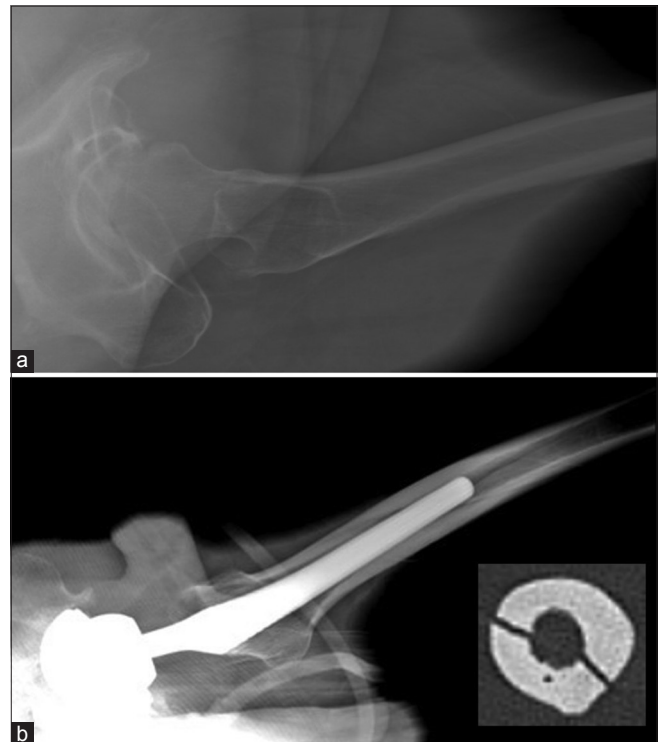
Cross-table lateral hip radiographs of a 68-year-old female (a and b). (a) No radiolucent line is seen in the femoral diaphysis preoperatively. (b) At below the implant tip, oblique radiolucent line (white arrow) is seen postoperatively. (c) Subsequent 6 axial computed tomography images from distal to proximal shows a nutrient artery canal in the posterior cortex (the ostium of nutrient artery canal on the outer cortex, the course through the cortex, and the inner ostium)
